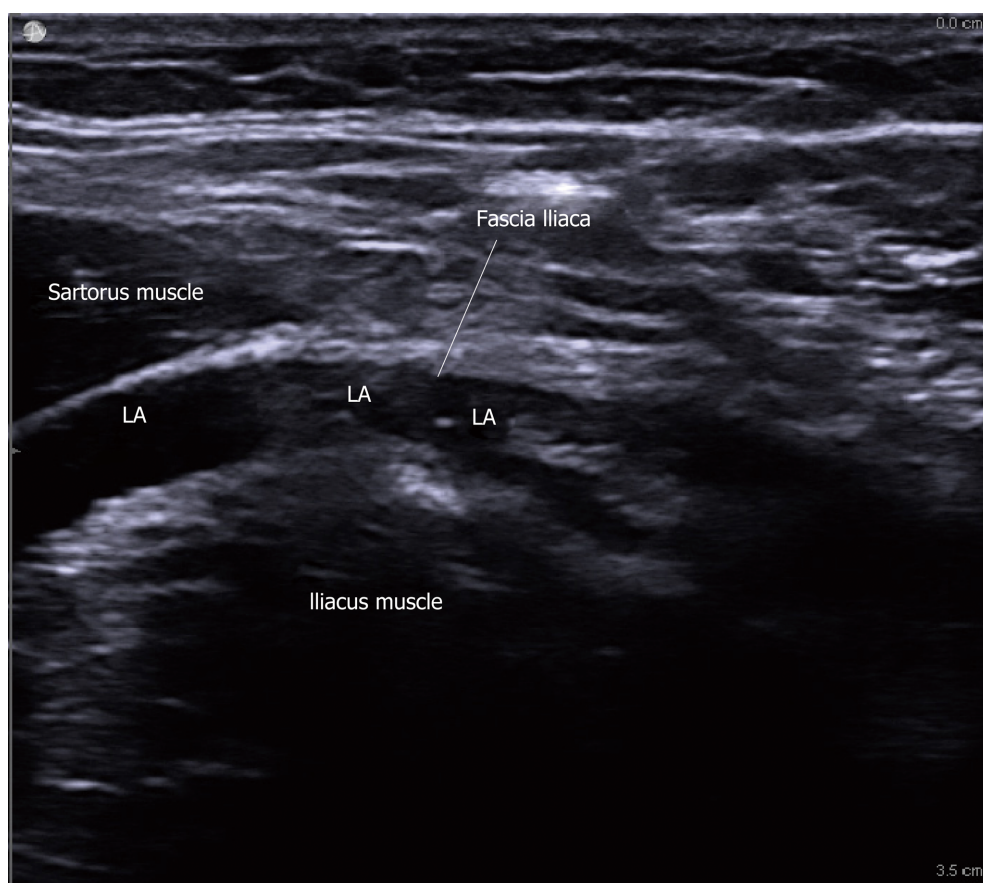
Ultrasound image of fascia iliaca plane block. Image is permitted and modified from Dr. Ali Shariat. LA: Local anesthetic injected beneath the fascia iliaca ligament.
